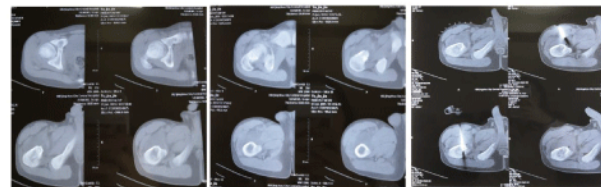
The imaging of CT showed tumor was suspected and the sarcoma could not be ruled out, and further examination is recommended.
